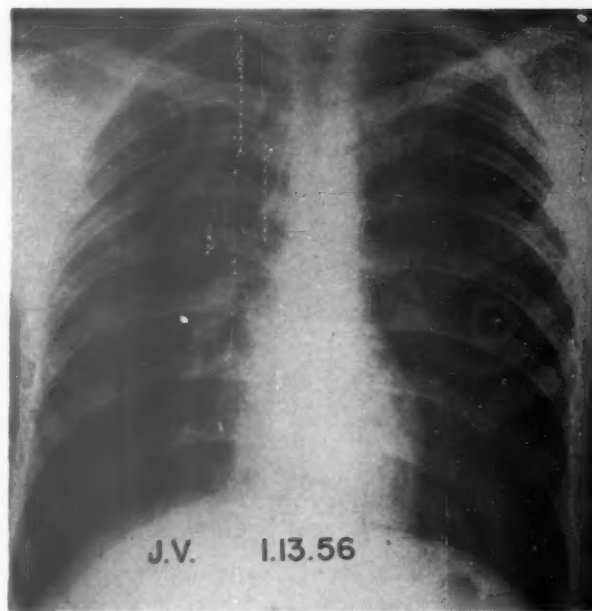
Chest roentgenogram of subject J. V., a twenty-one year old Marine. This individual, whose functional data are shown in Table V, was not included in this study because all diffusion data were entirely within the normal range in spite of diffuse pulmonary involvement by roentgenogram.
